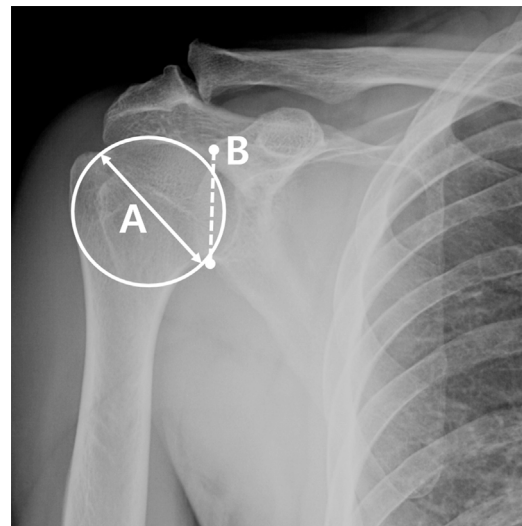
Scapula anteroposterior radiography. Measurement of humeral head: the diameter (A, arrow line) of largest circle in the humeral head, measurement of glenoid length: The distance (B, dotted line) of connecting the most superior and inferior points of the glenoid.
